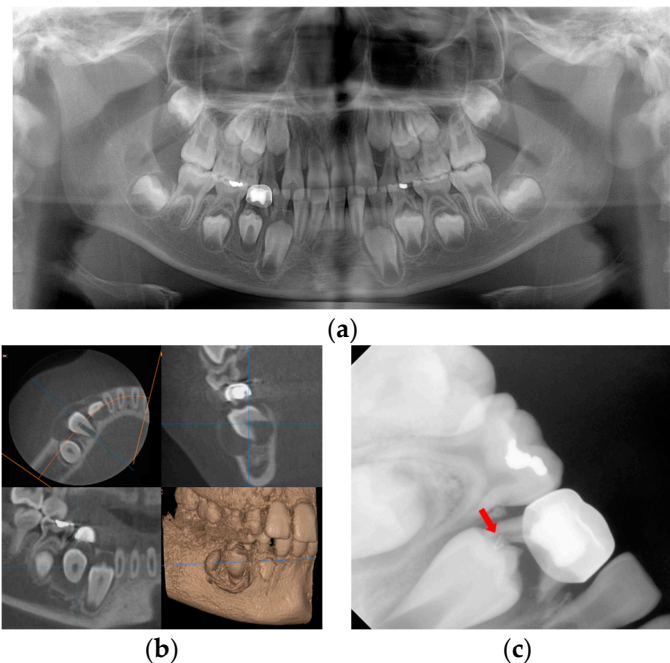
Initial visit: (a) panoramic radiograph; (b) cone-beam computed tomography; the cystic lesion around the successive right mandibular first premolar can be seen and the buccal bone swelling are observed; (c) periapical radiograph. A broken file is noted on the distal root tip of the affected primary molar (red arrow).
